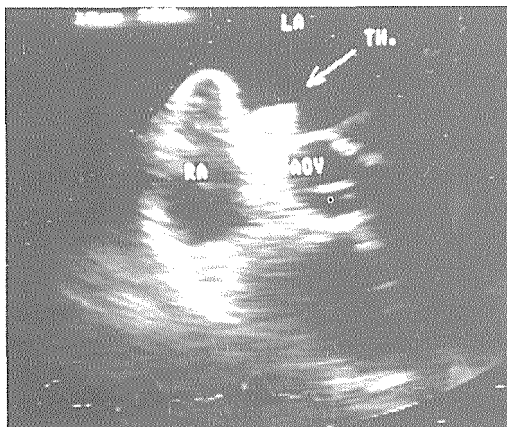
Transesophageal transverse-axis image in a patient with dilative cardiomyopathy. A large thrombus (TH) attached at interatrial septum is clearly visible (arrow). On the precordial image no definite structure could be visualised. LA = left atrium, RA = right atrium, AOV = aortic valve.
